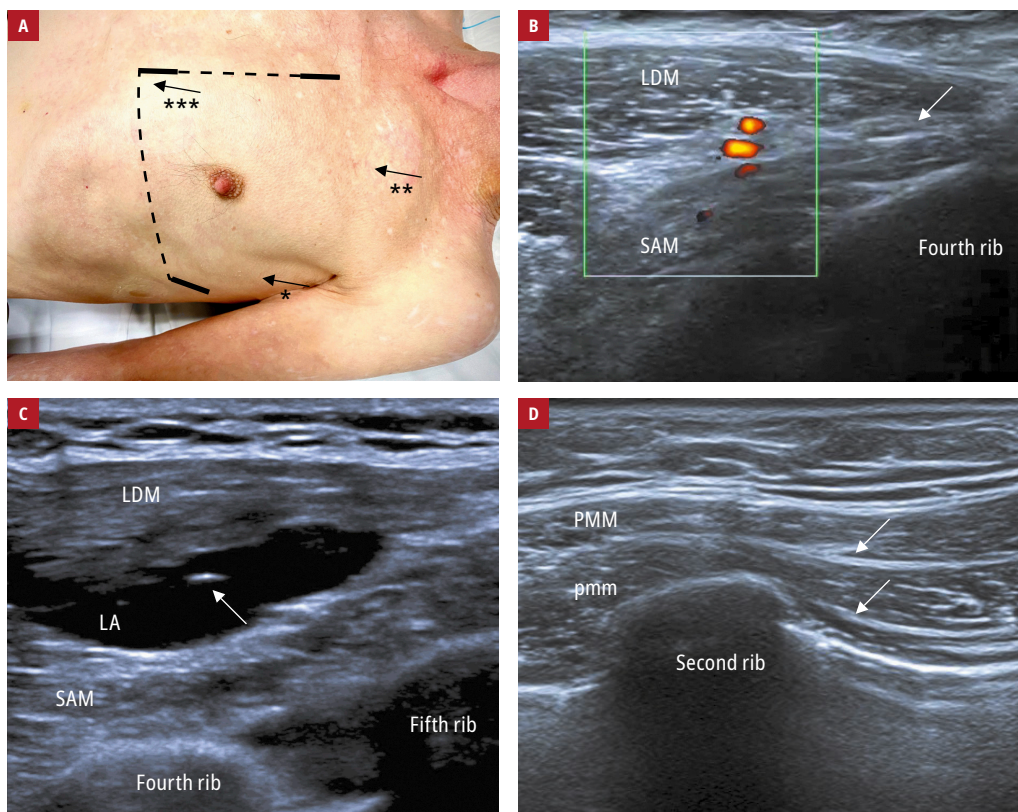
A – an image showing the incision line, tunneling lines (dotted line), and injection points for serratus anterior plane block (*), pectoral nerve block II (), and parasternal block (*); B – the serratus anterior muscle (SAM), latissimus dorsi muscle (LDM), and thoracodorsal artery (red marks); color Doppler ultrasound, interfascial plane (arrow). Before each insertion of the needle, blood vessels were identified and assessed to eliminate the risk of accidental injury; C – ultrasound of the SAM, LDM, and local anesthetic (LA). The position of the tip of the needle (arrow) was confirmed by low resistance infusion of saline solution and enlargement of biconvex-shape hydrodissection of the interfascial planes during infusion; D – ultrasound of the pectoralis major muscle (PMM) and pectoralis minor muscle (pmm). For pectoral nerve block II, LA was deposited in the interfascial planes (arrows).
